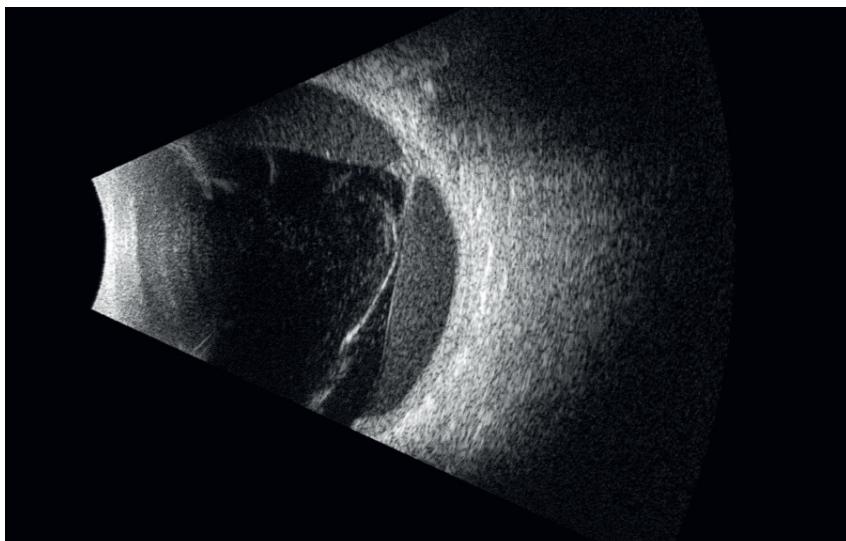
Vitreoretinal traction with pre-retinal hemorrhage visible in the ultrasound examination of the eyeball.
